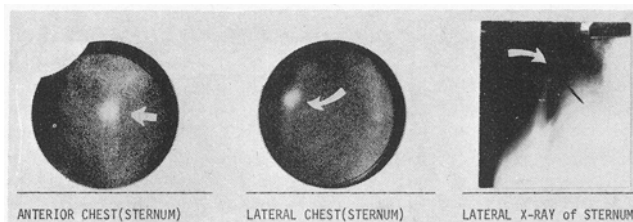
Patient in study complained of pain in midchest area about sternum. Original radiographs were normal. Isotopic bone study revealed increased activity in area of complaint and subsequent x-rays confirmed diagnosis of fracture in sternum.
